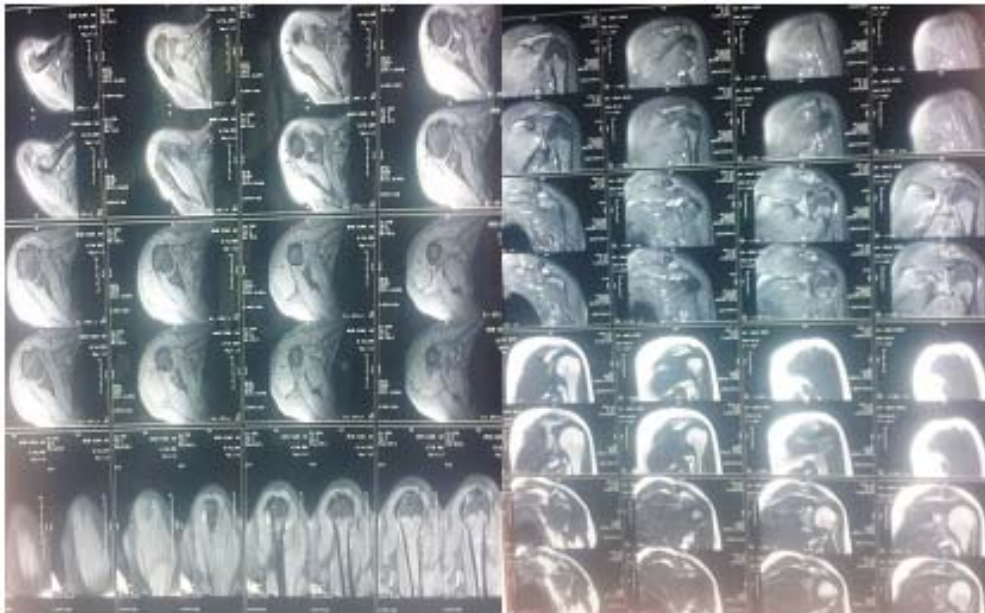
MR imaging of the shoulder structures
